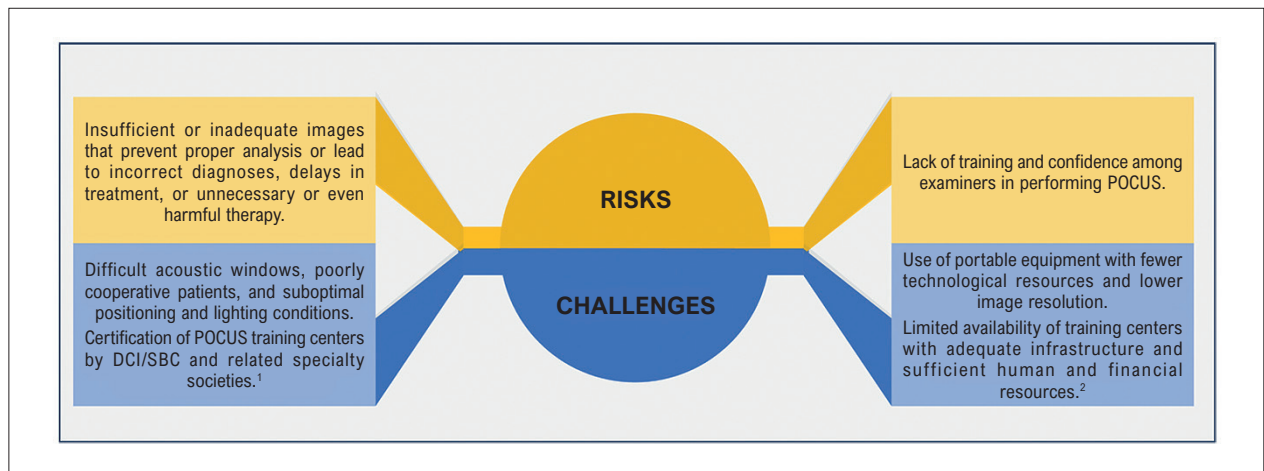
Risks and challenges involved in POCUS. The scope of POCUS extends beyond cardiac assessment and may require collaboration with other specialists, in addition to echocardiographers, such as vascular specialists, radiologists, intensivists, and pediatric cardiologists.¹ At present, no reimbursement mechanisms for POCUS have been established, and dedicated funding from training centers remains unavailable.²
